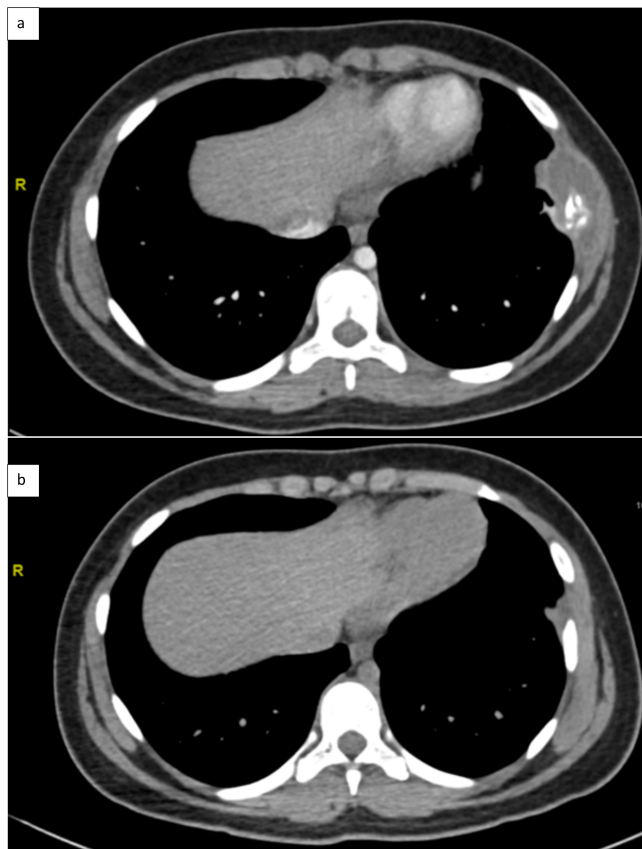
Thoracic CT scan (a) at diagnosis (b) end of treatment. Origin and source of radiology images: Department of Radiology CHU Dijon.
